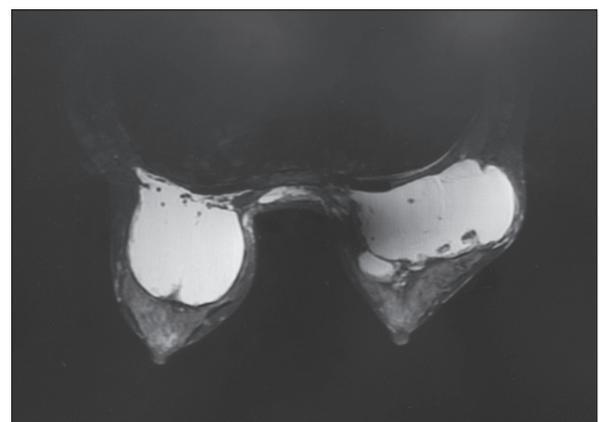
The MRI of breasts with polyacrylamide hydrogel (PAHG) injection. In the axial T2-weighted images with fat depression, PAHG shows a bright high signal because of its hydrophilic property, which is significantly contrasted with surrounding tissues, and can clearly show its location.
